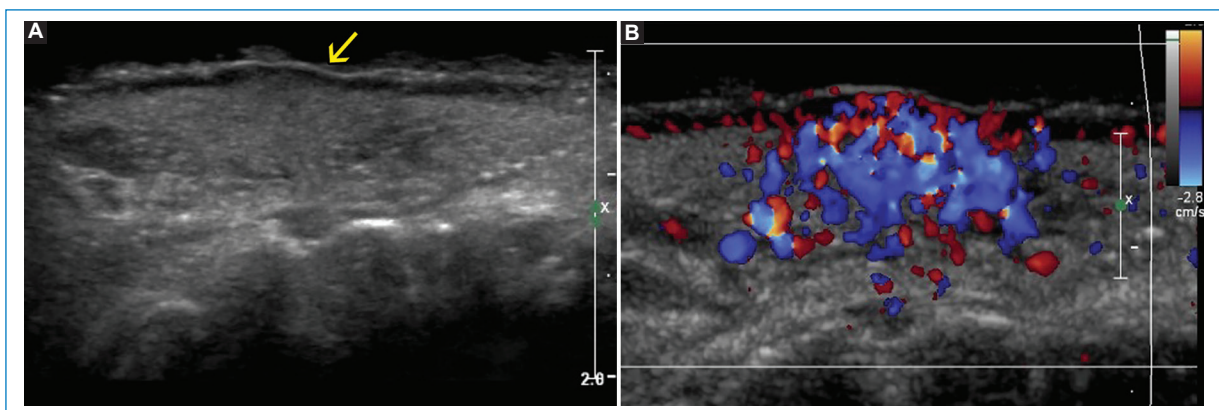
This patient had a lump that was examined with ultrasound. A hypertrophy of the soft tissues was seen in the grayscale image (A), a frequent characteristic of this type of lesion, and a vascular tangle with arterial and venous flow was seen in color Doppler mode (B).
